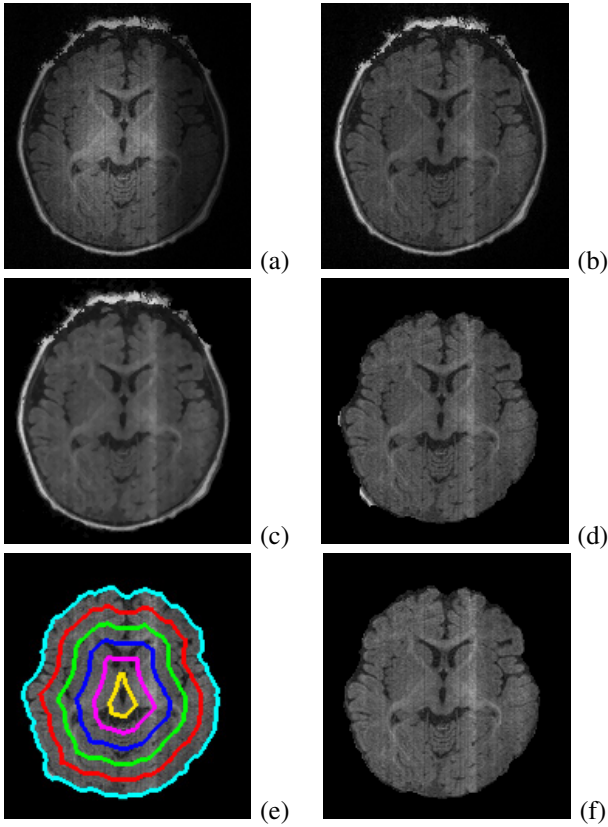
Step-wise brain extraction using our framework: (a) the original MR image, (b) the bias-corrected image, (c) the GGMRF-edge preserved image obtained with $\rho = 1$, $\lambda = 5$, $\beta = 1.01$, $\alpha = 2$, and $\eta_{s,r} = \sqrt{2}$, (d) the extracted brain using BET [4], (e) the iso-surfaces used to remove non-brain tissues, and (f) the final extracted brain.
